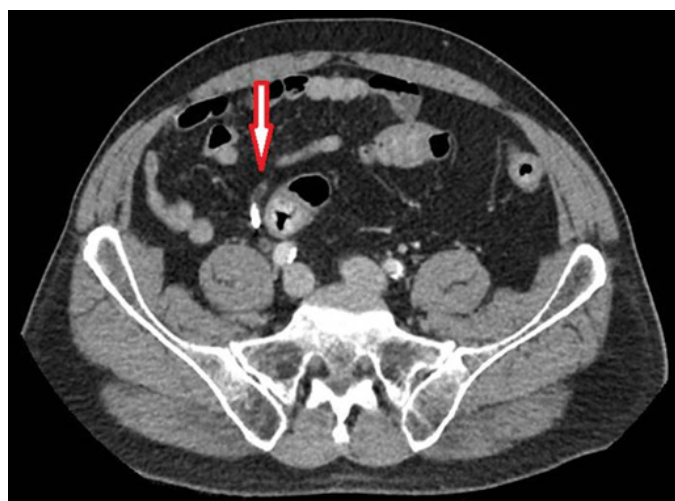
Axial computed tomography scan of the abdomen with IV contrast demonstrating barium retained in the appendix without edema of the appendix or inflammation in the periappendiceal fat. The tip of the appendix contains no barium and is normal (arrow).
